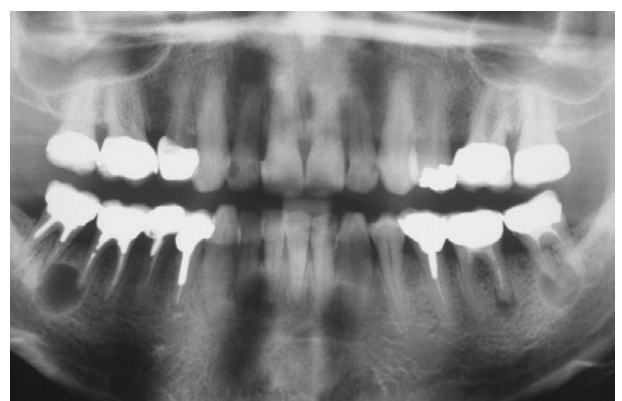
Inadequate and under-sealed endodontic treatments are often associated with periapical pathology.
